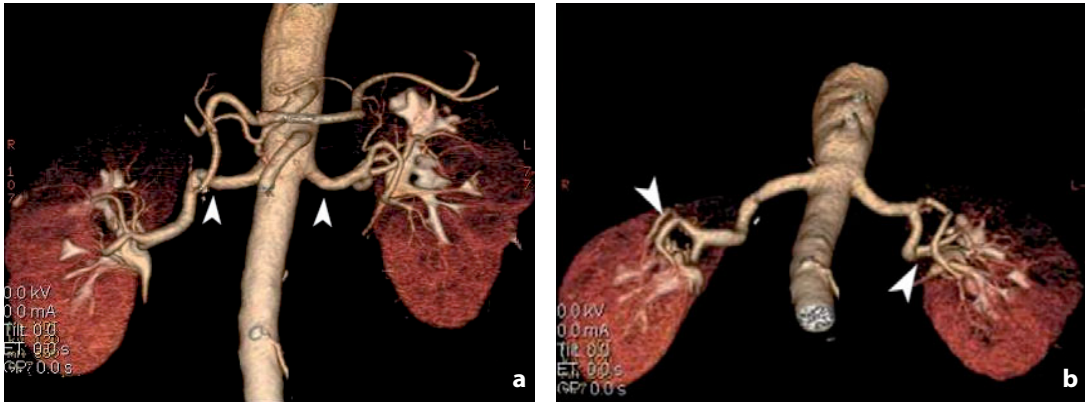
Computed tomography. VR reconstructions of the aorta and renal arteries. a The *arrowheads* indicate the renal arteries, which are visualized right up to their hilar subdivision (b)
